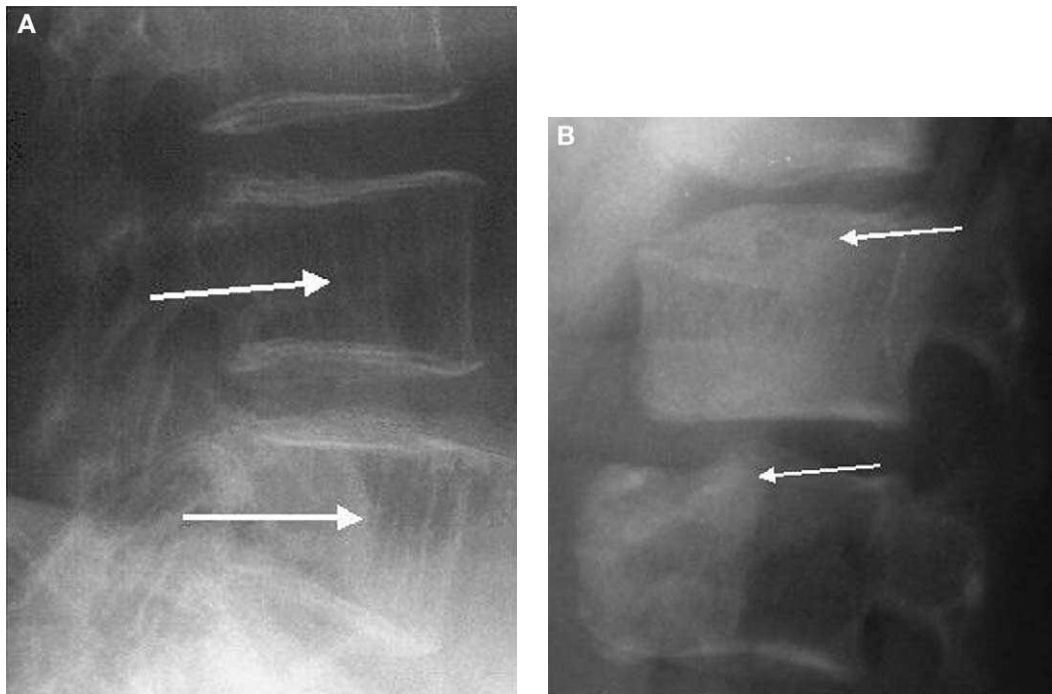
Differential diagnosis, conventional spine radiographs. (A) Osteoporosis presents with a coarse trabecular bone structure similar to vertebral hemangioma (hypertrophic atrophy) (arrows). (B) Deformity of multiple vertebrae caused by Scheuermann’s disease with fractured endplates and nonossified apophyses (arrows).
